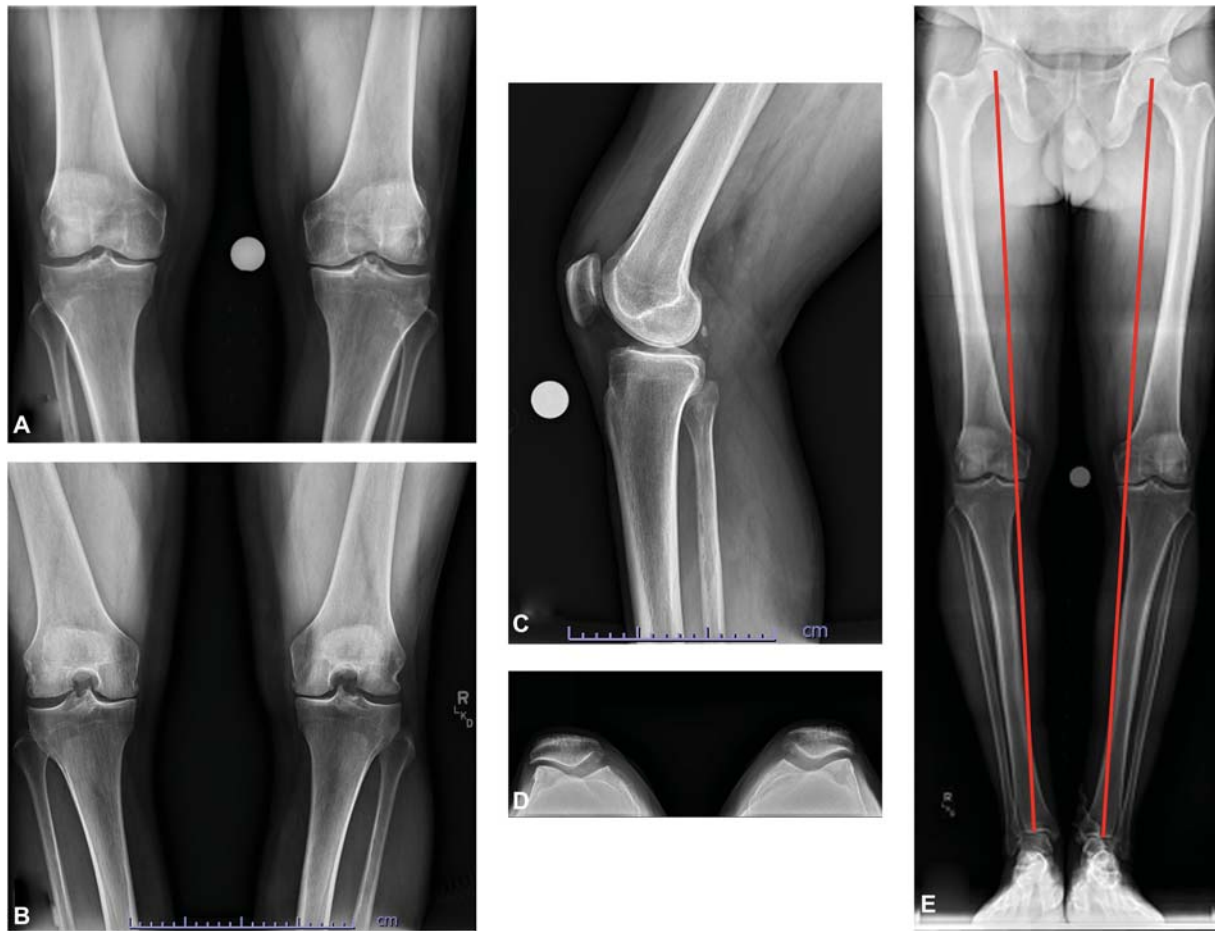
Standard knee radiograph series including (A) weight-bearing AP, (B) PA flexion, (C) lateral, (D) Merchant, and (E) standing hip to ankle alignment view with the mechanical axis indicated by the red line. AP, anterior to posterior; PA, posterior to anterior.
